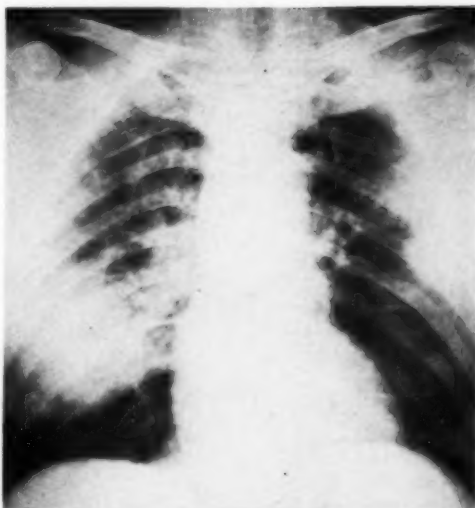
Case IX (L. T.): Roentgen examination on day of admission reveals dense consolidation occupying the central portion of the right lung field, indicative of an acute pneumonic process.
